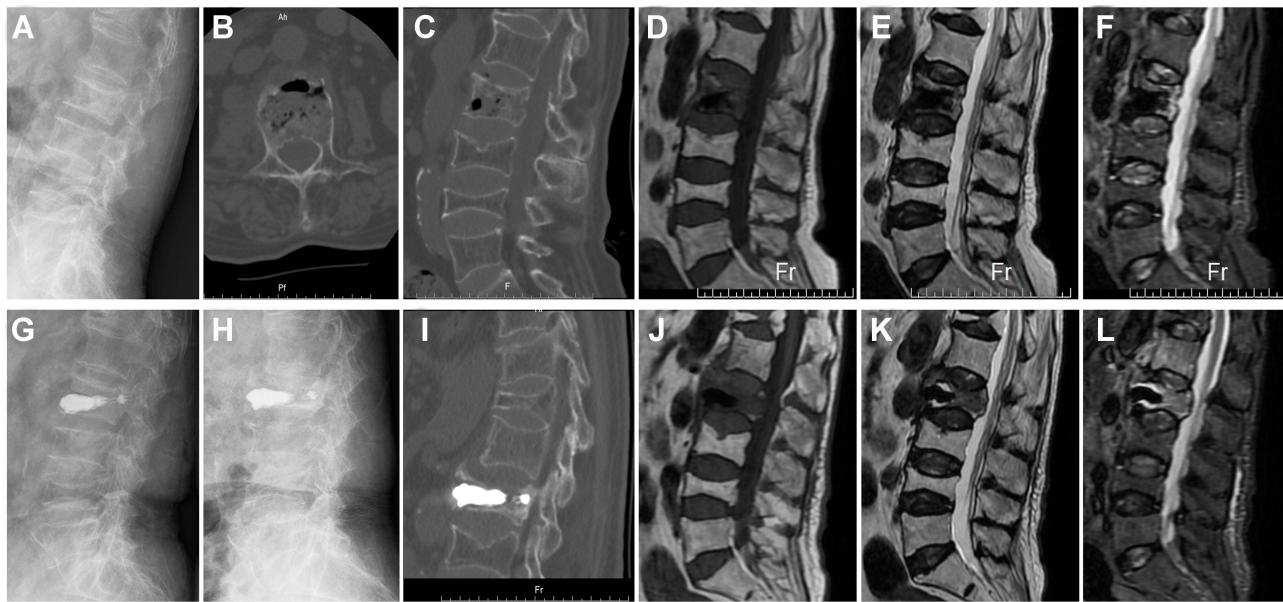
Bone cement loosening and displacement after traditional PVP in a patient with Kummell's disease. A female 82 years of age complained of "low back pain and discomfort for 2 months". (A) The preoperative lateral X-ray suggested a reduction in the height of the L2 vertebral body. (B and C) Preoperative CT revealed dehiscence of the anterior middle region of vertebra L2 and formation of a vacuum fissure within the vertebra. (D–F) Preoperative magnetic resonance imaging (MRI) confirmed that the L2 vertebral body was a fresh fracture. Also, the vacuum fissure in the vertebral body evidenced a fluid signal. (G) An X-ray taken on the first day after surgery showed that the bone cement filled the fissure in the middle of the anterior vertebral body, and that the vertebral body height was good. (H and I) Three months after operation, an X-ray and CT showed that the height of the L2 vertebral body was obviously less, and the vertebral body cement appeared to be displaced forward. (J–L) Three months postoperatively, MRI revealed a liquid signal around the bone cement.
